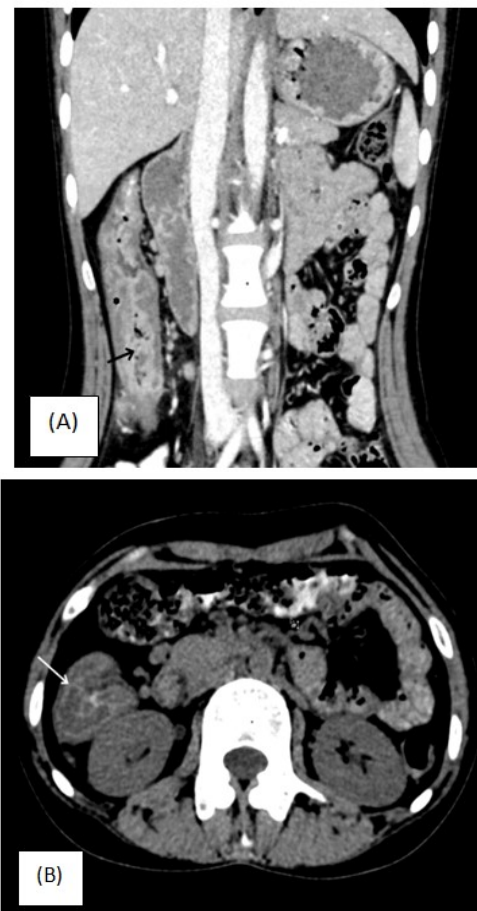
(A) Typhlitis (Water halo attenuation). Coronal contrast enhanced CT scan shows marked symmetrical circumferential bowel wall thickening with hyperenhancing mucosa with ulcerations (black arrow) with relatively non-enhancing submucosal (asterisk) - submucosal edema. (B) Axial contrast enhanced CT scan in the same patient shows peripheral hyperenhancing wall with submucosal edema
